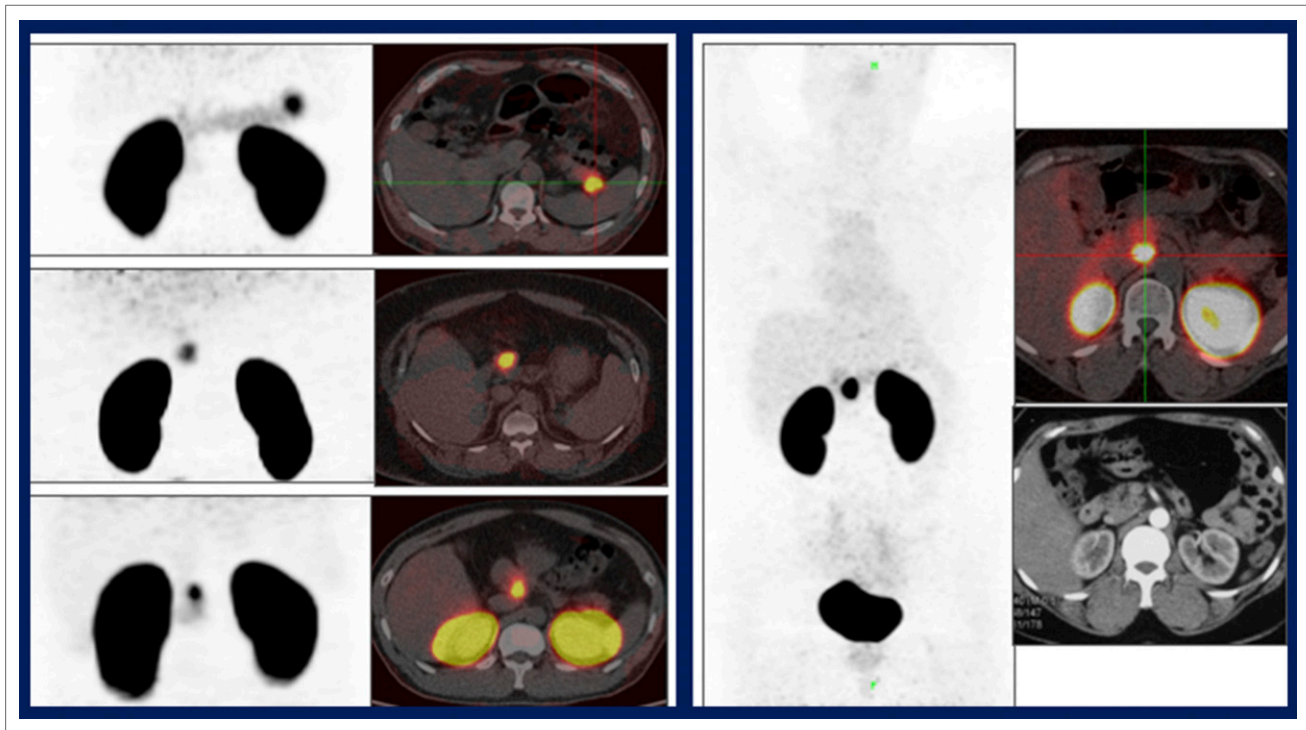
^{68}Ga -exendin-4 PET/CT (right images in the right and left blocks) in 4 patients in whom previous surgery failed to remove insulinomas and in whom contrast-enhanced CT with perfusion, MR, endoscopic ultrasound, and somatostatin scintigraphy (left images in the right and left blocks) were negative. The sensitivity, specificity, accuracy, and positive and negative predictive values for ^{68}Ga -exendin-4 PET/CT in diagnosing insulinoma were 99.0%, 100%, 99.3%, 100%, and 98.3%, respectively. After PET identification of insulinomas, patients underwent surgical removal or ethanol ablation.
